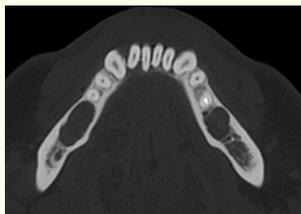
CT-scan revealed two different sized radiolucent cystic lesions. The smaller one was located in the region 36 and with a diameter of 1 cm, whereas the larger one was situated in 46-47 with a diameter of 2 cm. Thinning of the mandibular cortex is seen, cortical border is still defined as a thin rim.
